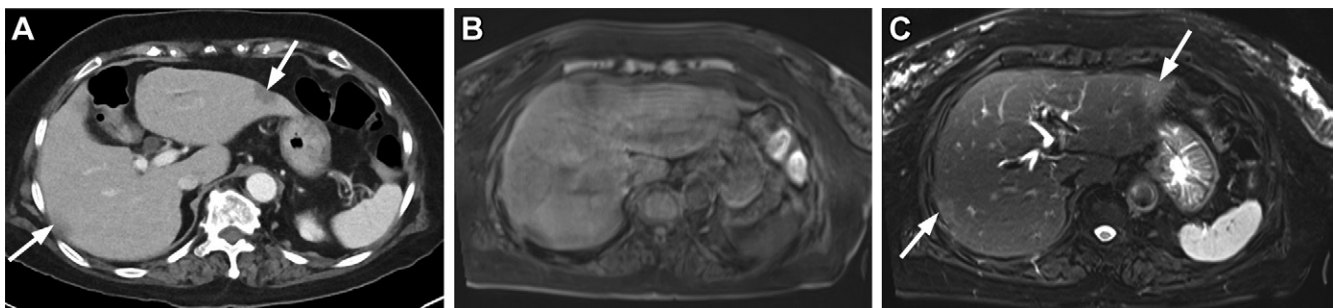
Images in a 96-year-old woman with acute abdominal pain. (A) Axial contrast-enhanced CT scan of the abdomen shows two low-attenuation lesions (arrows) in segment II of left lobe and segment V and/or VI of the right lobe of liver. (B) Initially acquired axial conventional breath-hold T1-weighted gradient-echo MRI scan shows avidly enhancing lesions in both lobes. Image shows significant motion artifacts, limiting accurate lesion characterization. (C) T2-weighted fat-saturated MRI scan acquired using a commercially available gated navigator sequence (prospective acquisition correction technique [PACE, Siemens]) helps mitigate motion artifacts and delineate the T2 intermediate character of the two lesions (arrows).
